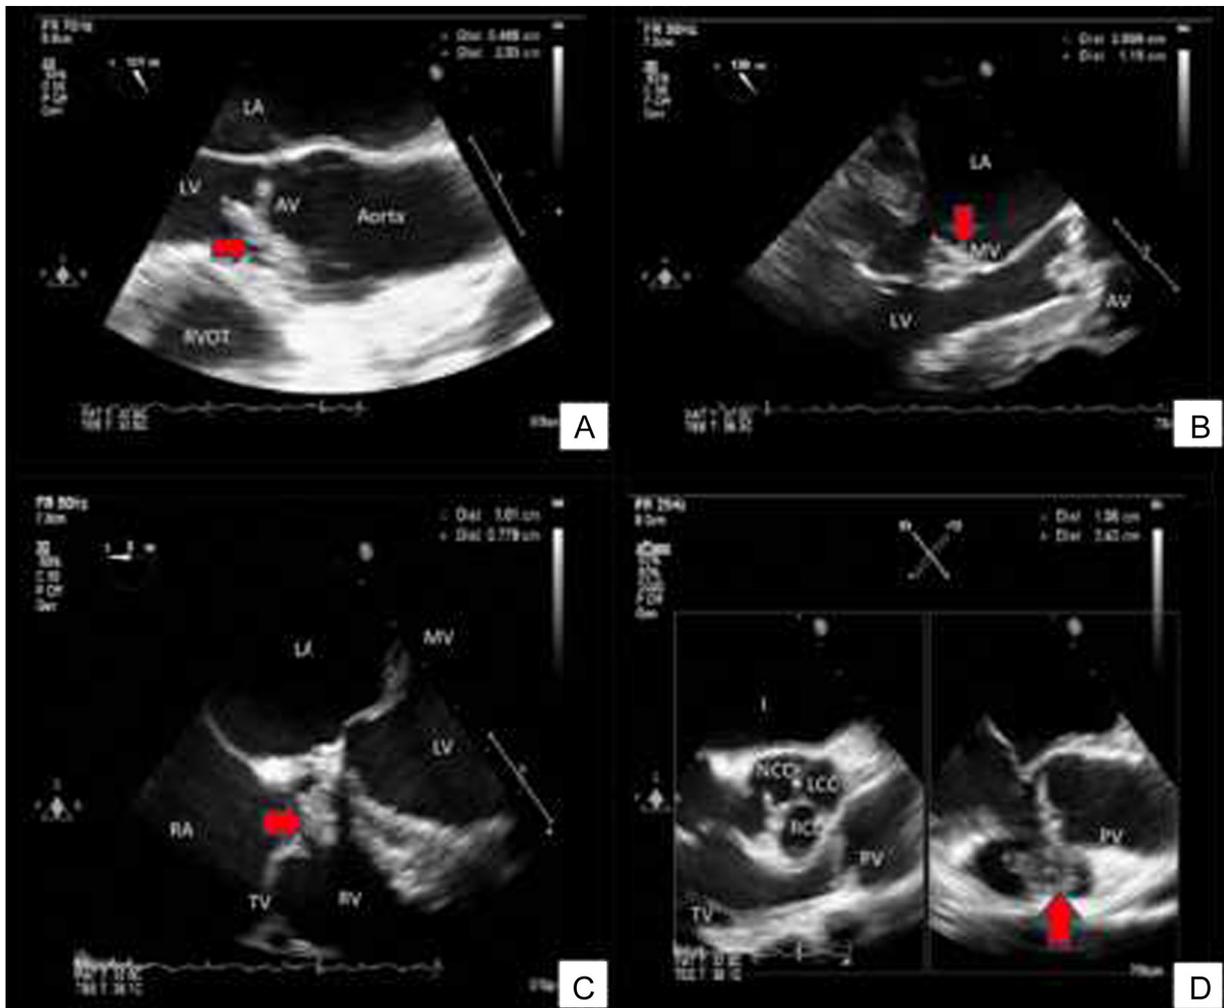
Echocardiographic pictures with red arrows showing (A) aortic valve mass $2.0 \times 0.4 \text{ cm}$ (long-axis view), (B) mitral valve mass $1.1 \times 0.6 \text{ cm}$ (long-axis view), (C) tricuspid valve $1.0 \times 0.7 \text{ cm}$ (4-chamber view), and (D) pulmonary valve mass $2.4 \times 1.0 \text{ cm}$ (short-axis view). LA = left atrium; LV = left ventricle; RA = right atrium; RV = right ventricle; MV = mitral valve; AV = aortic valve; TV = tricuspid valve; PV = pulmonary valve; LCC = left coronary cusp; RCC = right coronary cusp; NCC = noncoronary cusp.
